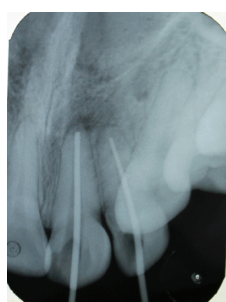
Master cone radiograph (After 5 months of intracanal medication)
